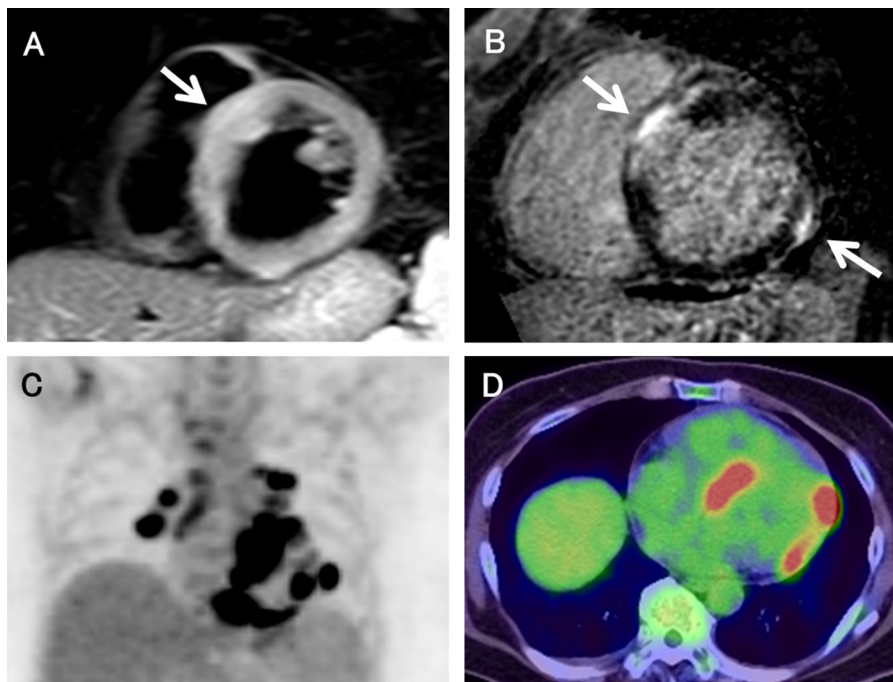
T2-weighted cardiac magnetic resonance (CMR) showed high-intensity signal areas and wall thickening at anteroseptal wall of the left ventricle (arrow) (A). CMR imaging demonstrated late gadolinium enhancement at the anteroseptal and lateral walls of the left ventricle (arrow) (B). ¹⁸F-fluorodeoxyglucose positron emission tomography images demonstrating abnormal uptake in the hilar lymph nodes and the anterior and inferior wall of the left ventricle (C), horizontal plane, the interventricular septum and the lateral wall of the left ventricle (D).
